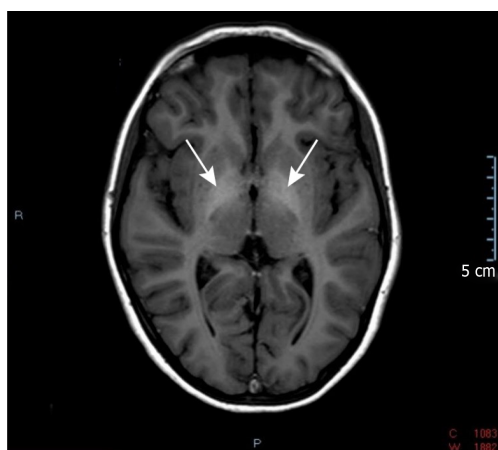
Axial T1-weighted brain magnetic resonance imaging scan (case 5). Arrows indicate symmetrical T1-hyperintensity involving the bilateral globus pallidus.
